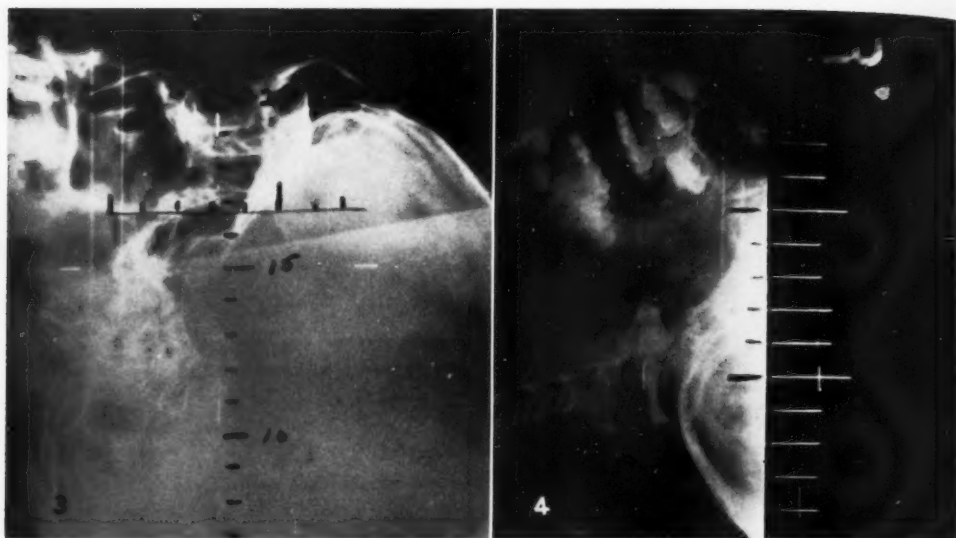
Lateral localization film of a patient with a pituitary tumor. Note the four opaque reference marks which define the position of the central ray. The scale of the "ruler" radiograph has been transferred to the film. This scale is also used to determine the second co-ordinate; in this case it may be chosen as 3 cm. cephalad to the external auditory canal plane. The first co-ordinate, distance above the table, would probably be taken as 15-cm.
